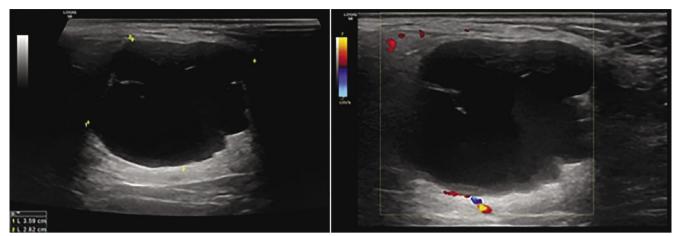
1st cleft cyst: in the inferior pole of the parotid gland one can observe a cystic-like lesion of multilobular borders, septa that are of low vascularity on color Doppler, and thick content, attached to the lateral borders
